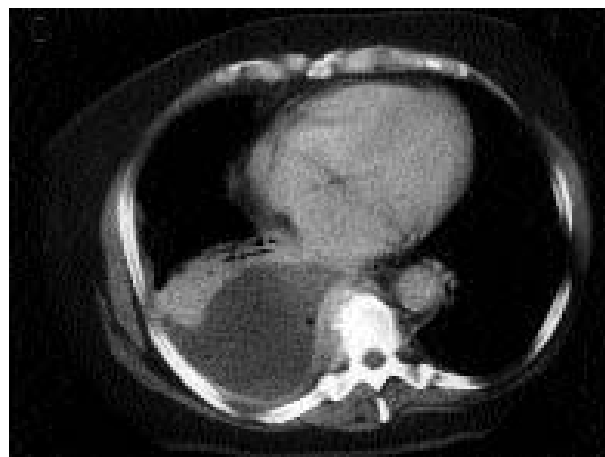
Computed tomographic (CT) image of the thorax (with intravenous contrast), at first presentation. The right hemithorax demonstrates loculated pleural fluid with thickening of the pleura. There is a small air bubble which seems to be trapped. Both findings are compatible with empyema. Furthermore, there is atelectasis of the right lower lobe. The thoracic vertebra on this level appears to be intact.
